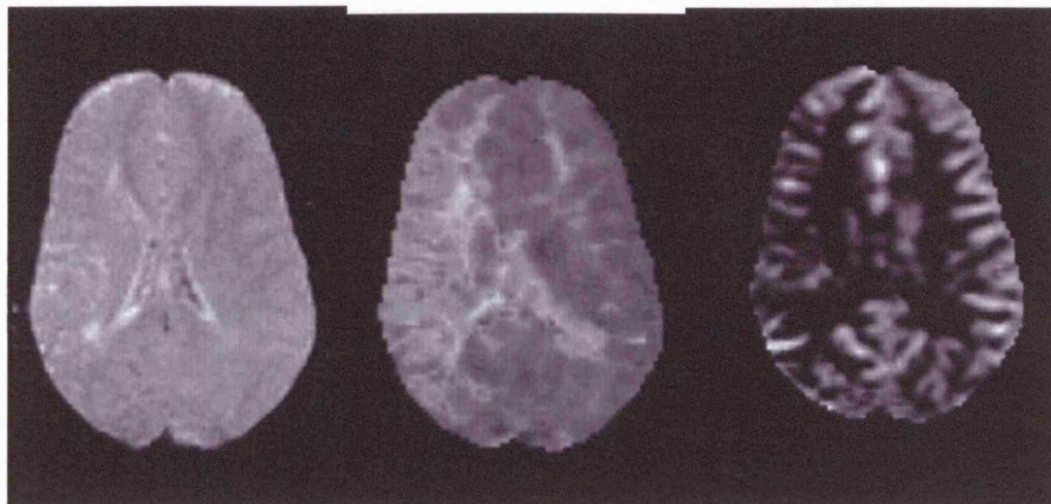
Ten-year-old patient with sickle cell anaemia, anterior territory TIA, seizures and headaches, on blood transfusion therapy. MRI: cerebral infarct (subcortical) in the anterior borderzone (MCA/ACA) region on the right. Perfusion MRI: severe increase in the mean transit time (MTT) of the passage of the Gadolinium bolus and decrease in the cerebral blood flow (CBF) in the right deep white matter (MCA/ACA territory). MRA: severe turbulence in the right MCA. TCD: maximum right MCA velocity: 220 cm/sec, and maximum left MCA velocity: 130 cm/sec.
